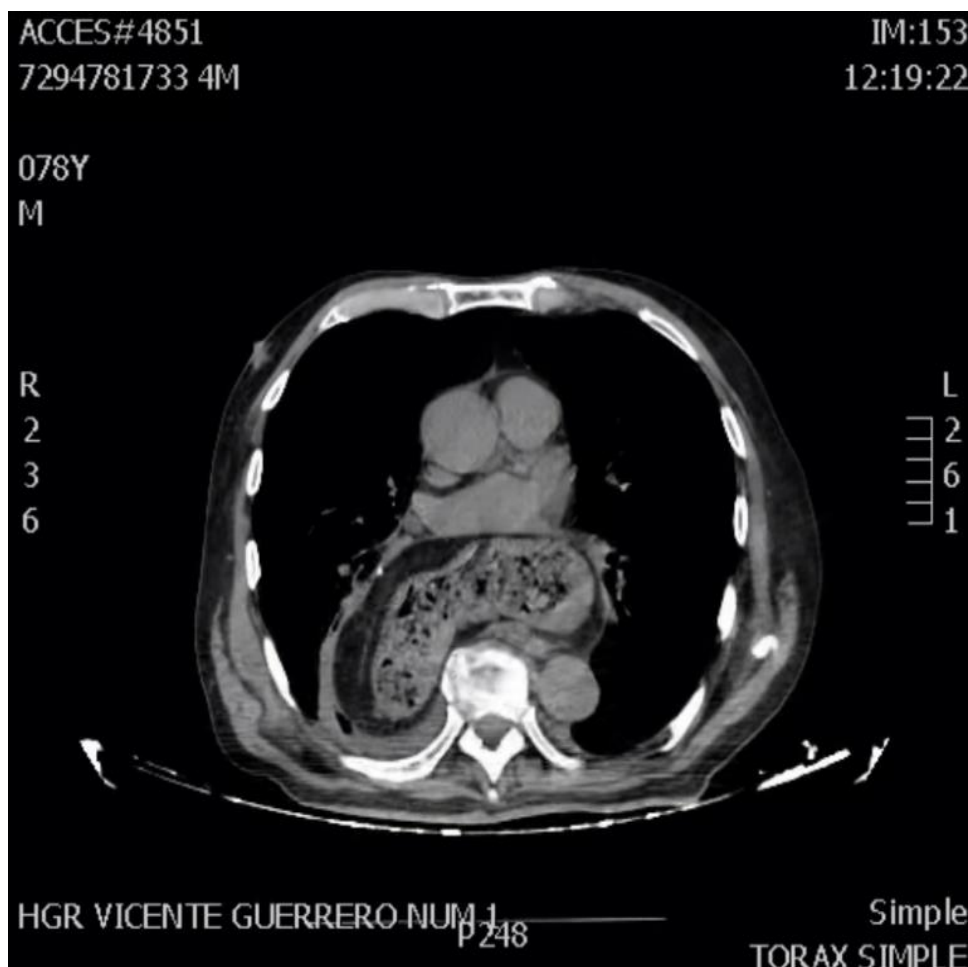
Thoracoabdominal CT showing intrathoracic stomach in axial section.
